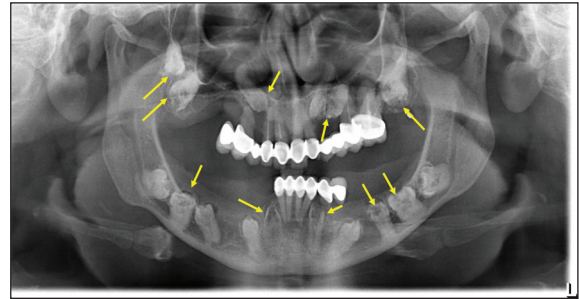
Unerupted 16 teeth; six in the maxilla and 10 in the mandible and pre-eruptive intracoronal resorption in 10 of them in panoramic radiography image (yellow arrow; various pre-eruptive intracoronal resorption defects).
